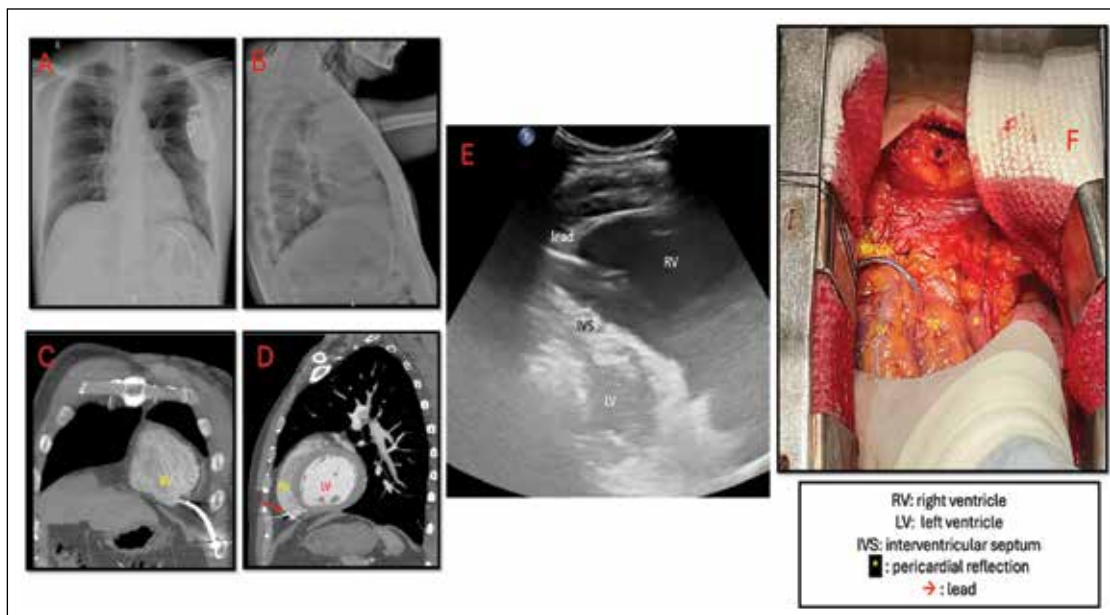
Chest radiographs of a patient with single coil AICD lead inserted for primary prevention in AP and lateral views, respectively (Panels A, B), Cardiac computer tomography in coronal and sagittal views, respectively (Panels C, D), Echocardiography modified four-chamber view showing lead perforation and exiting beyond the right ventricle lying above the diaphragm and within the pericardial sac. Panel F: An intraoperative image of the same case showed perforated lead with an even coil portion seen migrated beyond the RV within the pericardial reflection.
